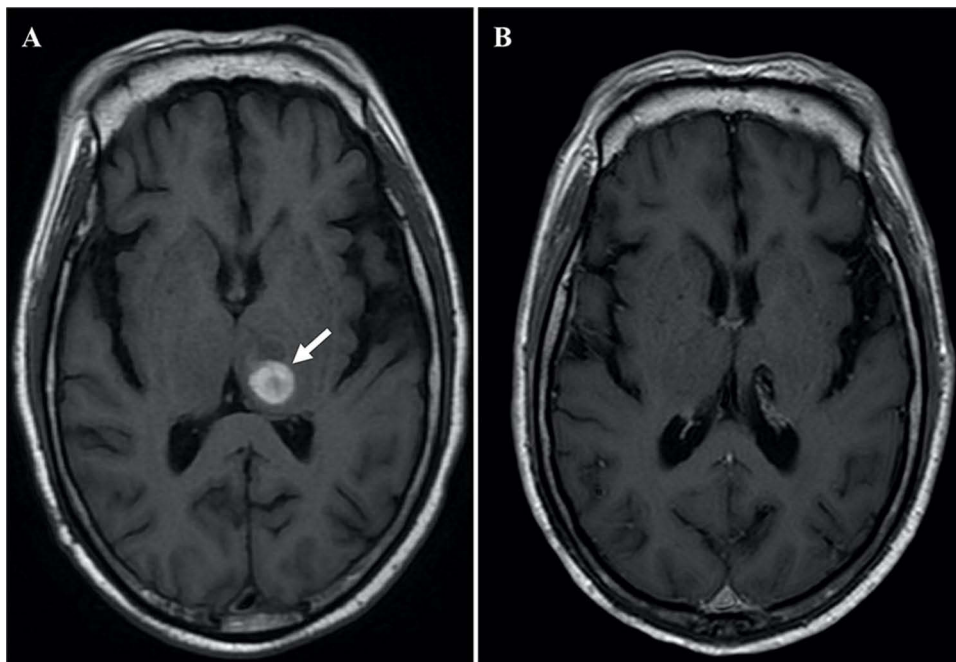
MRI scans displayed a metastatic lesion in the left thalamus before and after dacomitinib treatment. (A) Axial MRI scan showed a 2.2×1.6 × 1.5 cm lesion with mixed signal intensity (arrow), suggestive of a hemorrhagic metastatic lesion. (B) Axial MRI scan revealed complete remission of the previously noted metastatic lesion.
